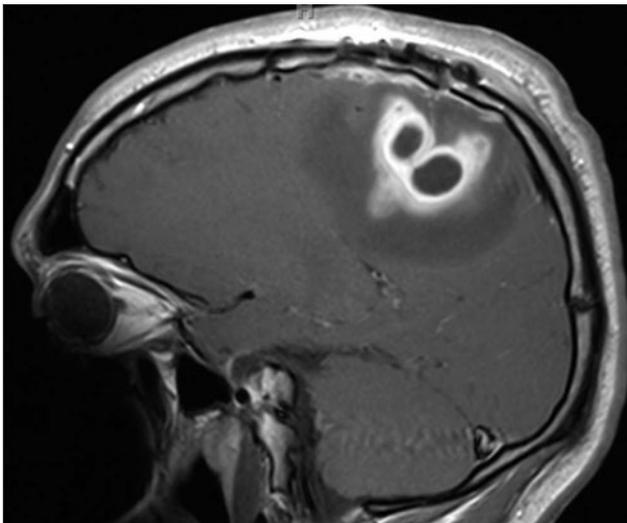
Sagittal T1-weighted magnetic resonance imaging sequence with gadolinium administration showing peripheral contrast enhancement surrounding a hypointense core.
